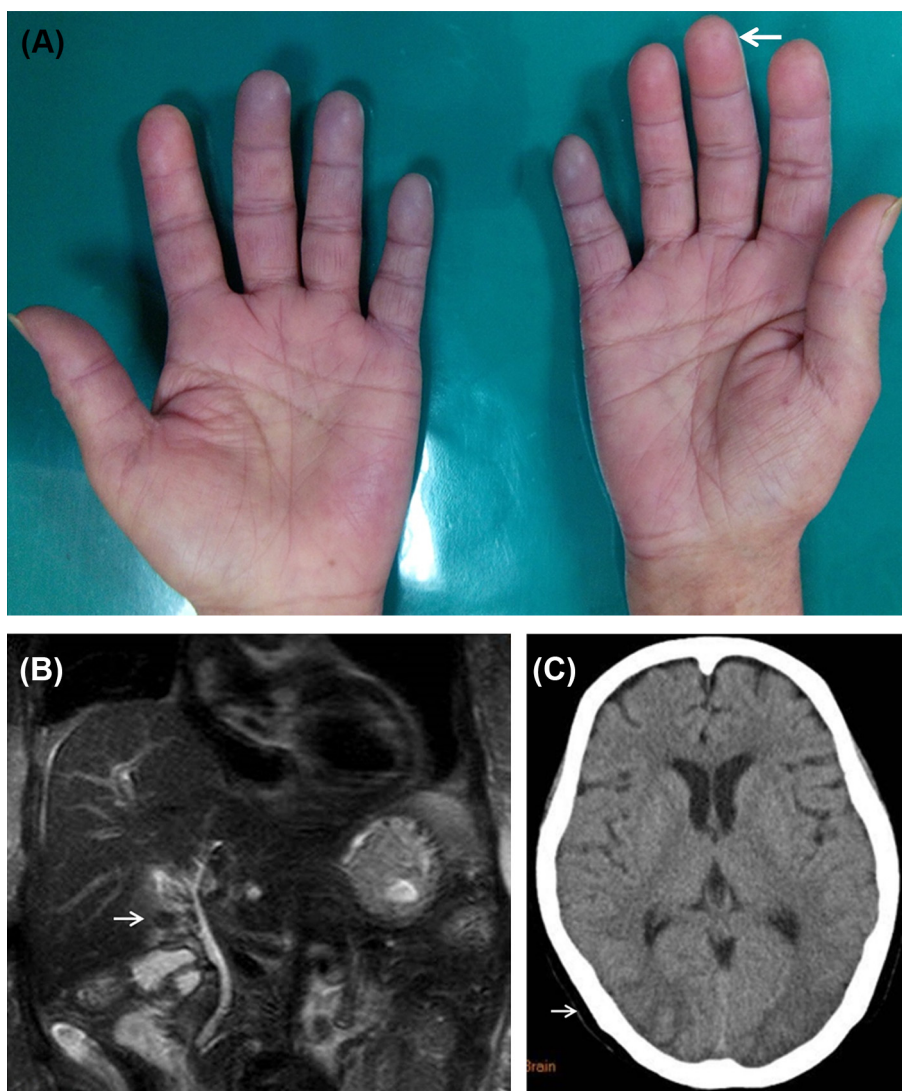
(A) The patient had Raynaud's phenomenon and digital pitting scar (white arrow). (B) The magnetic resonance cholangiopancreatography image shows gallstones (white arrow) with intact biliary duct. (C) The brain computed tomography images show a hypodense area in the occipital lobe, which is a characteristic of posterior reversible encephalopathy syndrome (white arrow).
